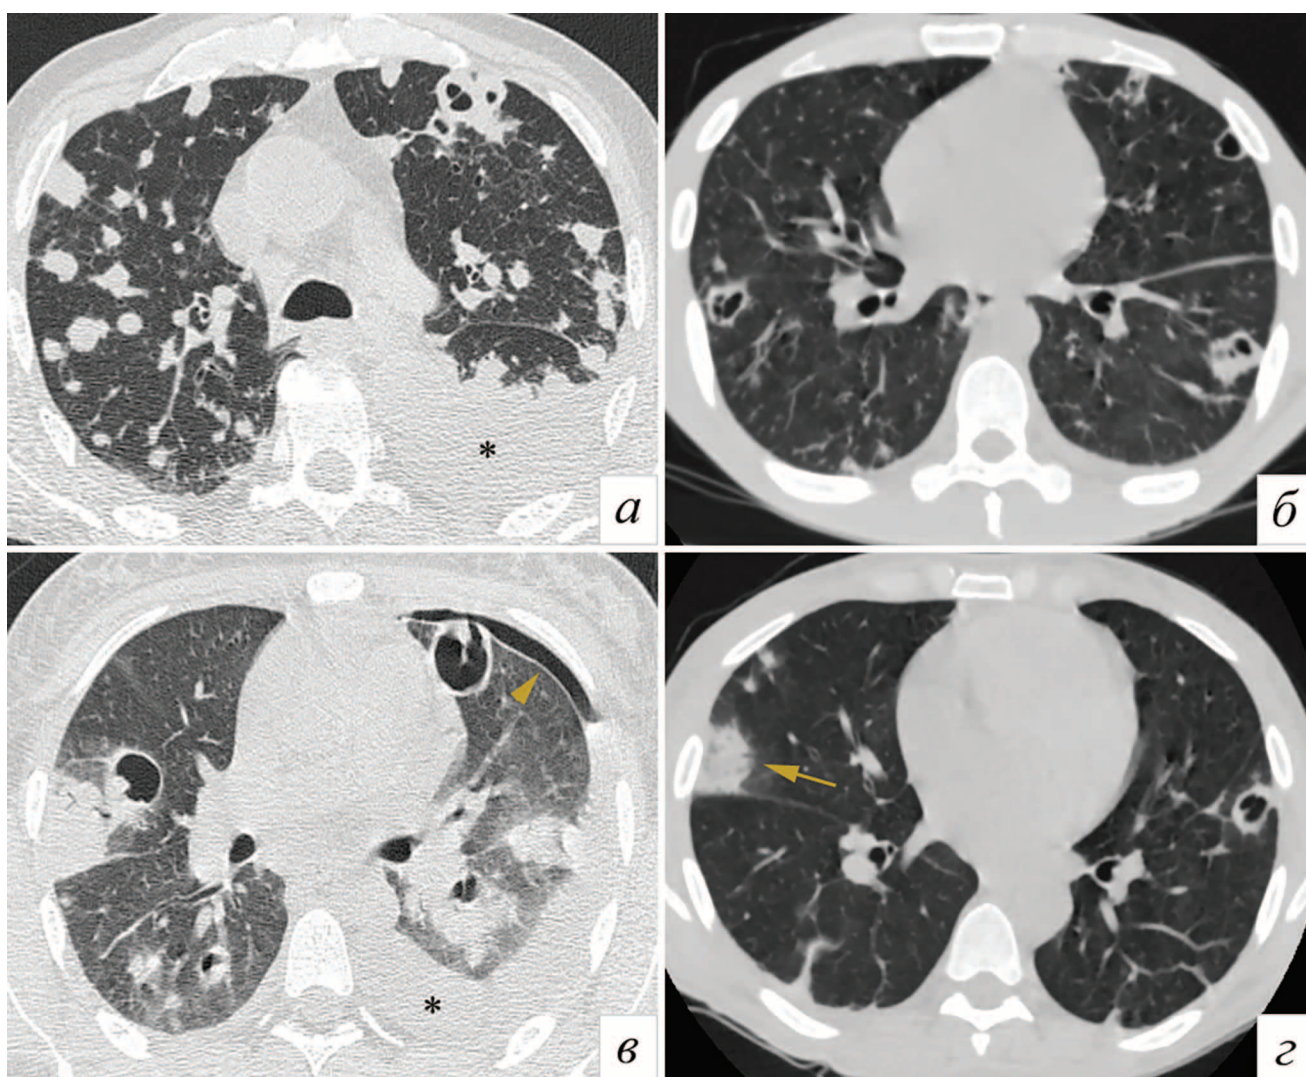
Transversal chest CT images of different patients with septic pulmonary embolism (SPE). In cases of SPE in various combinations chaotic nodules (a), thin-walled cavities in subpleural location (б-2), as well as opacities- consolidations (в) and a “reverse halo” sign (arrow) are observed. SEP can be complicated by effusion into the pleural cavity (*) and even pneumothorax (arrow head)
